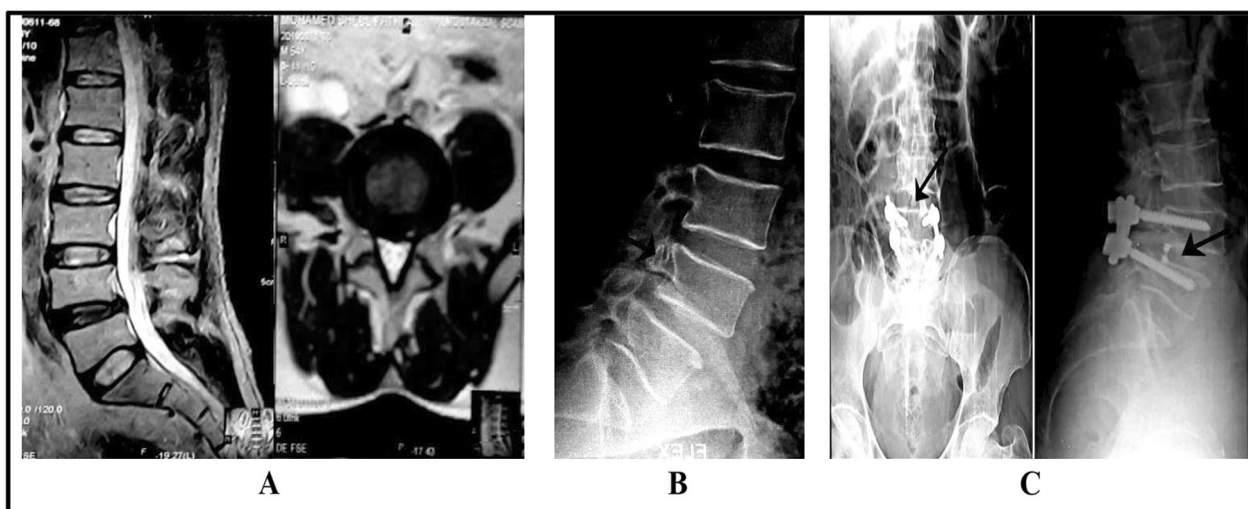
Adult patient above 50 years, presented with low back pain and claudication pain with no neurological deficit. Patient underwent decompression, stabilization and fusion using the Conventional Midline Approach. A Preoperative MRI of lumbosacral spine showing slippage of L4 over L5 and L4-5 diffuse disc prolapse; B Preoperative X-ray showing fracture pars at level 4,5; C Postoperative X-ray showing pedicle screws in L4 and L5; the arrow points to the cage
